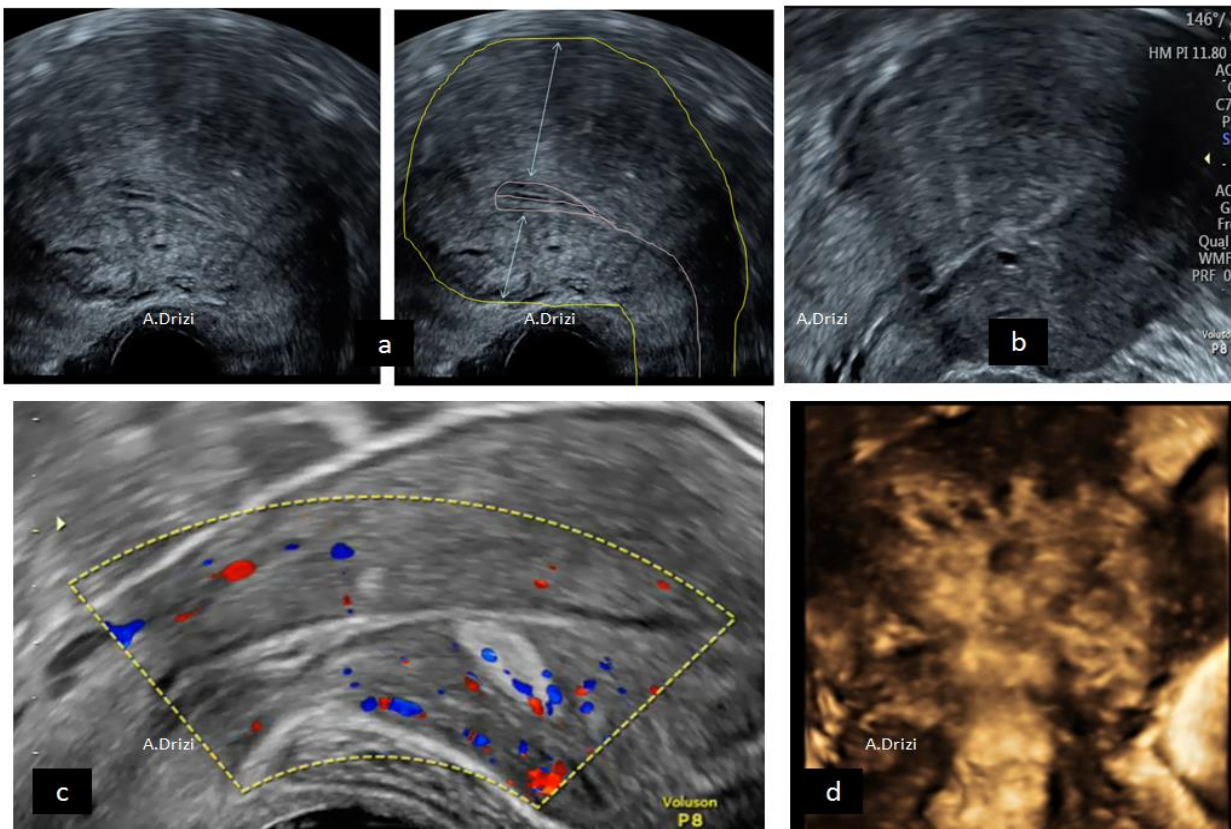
Ultrasonographic criteria of adenomyosis by the MUSA group: a: asymmetrical thickening, fan-shaped shadowing; b: cysts, subendometrial buds and lines; c: hyperechoic island, trans-lesional vascularity; d: irregular junctional zone.
